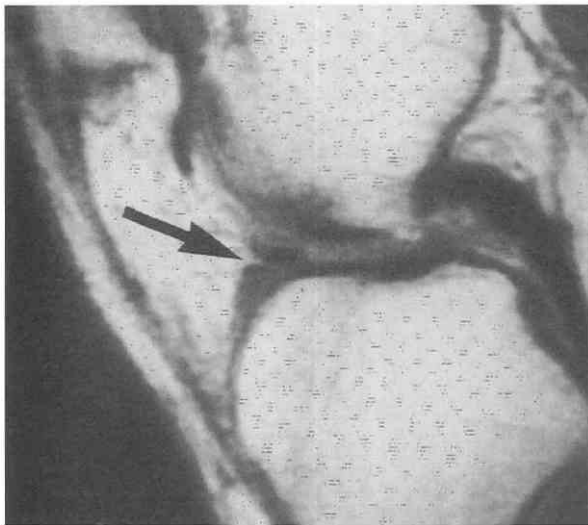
Normal anterior horn of the medial meniscus. Sagittal T1-weighted image shows the "arrowhead" configuration of the anterior horn of the medial meniscus. The "arrowhead" points posteriorly, with the lowermost anterior portion representing the anterior horn of the medial meniscus and the higher portion representing the transverse ligament attachment. The cleft in between should not be confused with a tear (*arrow*).
